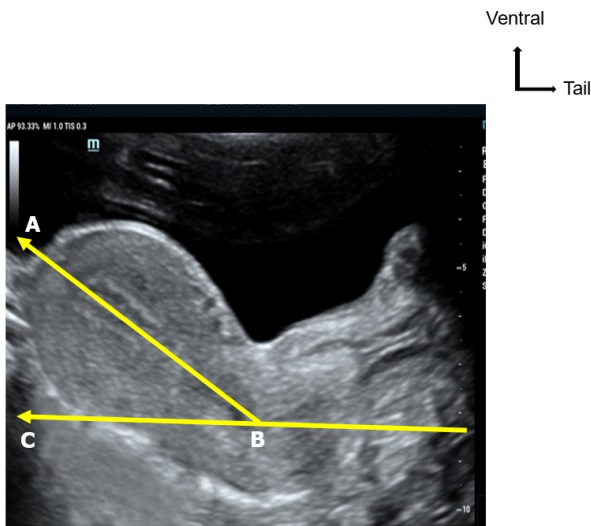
Ultrasound sagittal section of the anteverted uterus through the suprapubital approach showing the markers determining anteversion.
